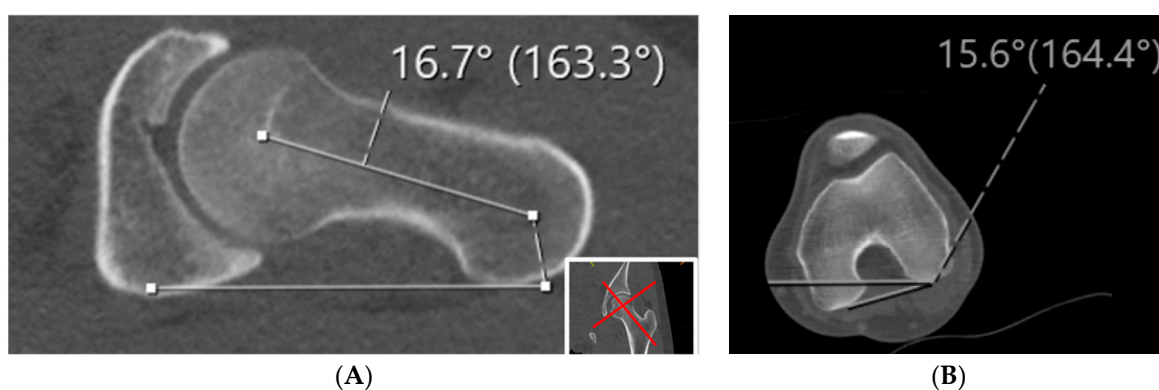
The Jarrett methods for measuring femoral version is demonstrated in the CT scan. As compared to other methods, the Jarrett method uses the axial oblique down the femoral neck to measure the proximal aspect of the femur. (A) Axial oblique as defined by the images in the bottom right corner to measure the angle perpendicular to the patient lying flat on the table with the line created down the femoral neck. This value is then added to angle measured in (B) in which the angle created by the femoral condyles is measured.
